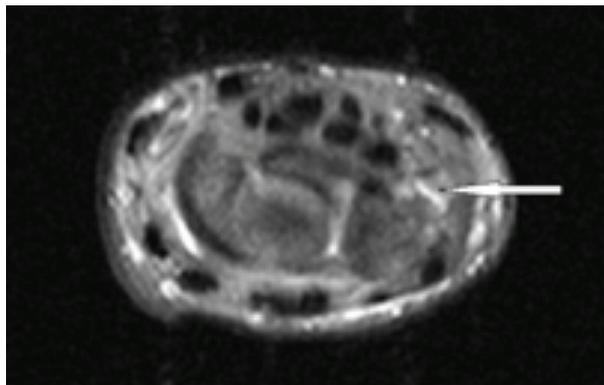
TFCC 1B lesion – ulnar avulsion without distal ulnar fracture (MRI, transverse plane, STIR).
